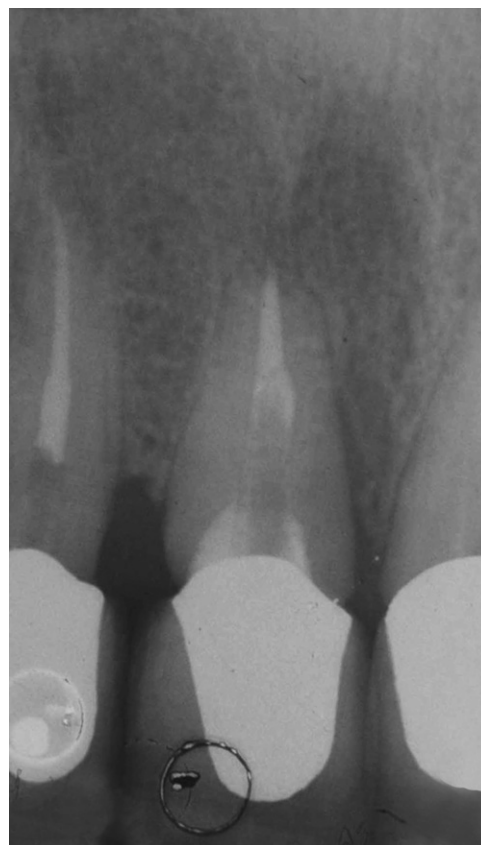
Preoperative radiograph of fractured tooth.
